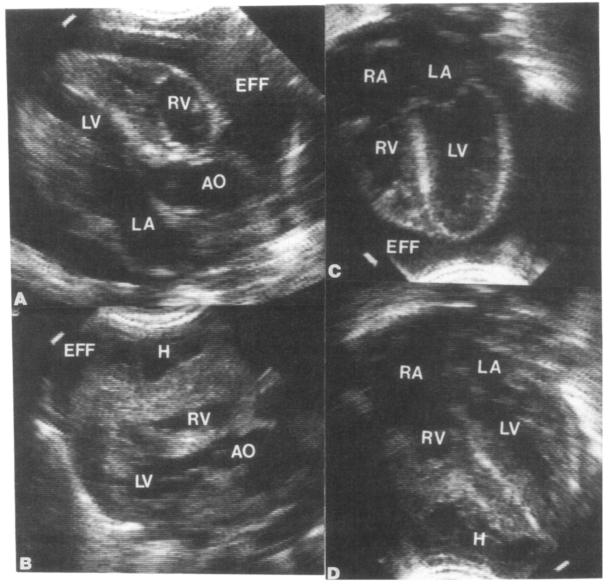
Two-dimensional echocardiographic images from the parasternal long-axis view before (A) and after (B) pericardiocentesis. Before pericardiocentesis, a large pericardial effusion (EFF) is seen anteriorly and posteriorly. After pericardiocentesis, a large subspicardial and intramyocardial echo-dense hematoma (H) is present. Note the severe compression of the right ventricular cavity by the hematoma. Two-dimensional echocardiographic images from the apical 4-chamber view before (C) and after (D) pericardiocentesis. Before the pericardiocentesis, a large pericardial effusion (EFF) is noted. After pericardiocentesis, a large echo-dense hematoma (H) is seen in the diaphragmatic surface of the right ventricle (RV) extending to the cardiac apex. There is near total obliteration of the RV cavity by the hematoma. AO = aorta; AD = left atrium; AD = left ventricle; AD = right atrium.
